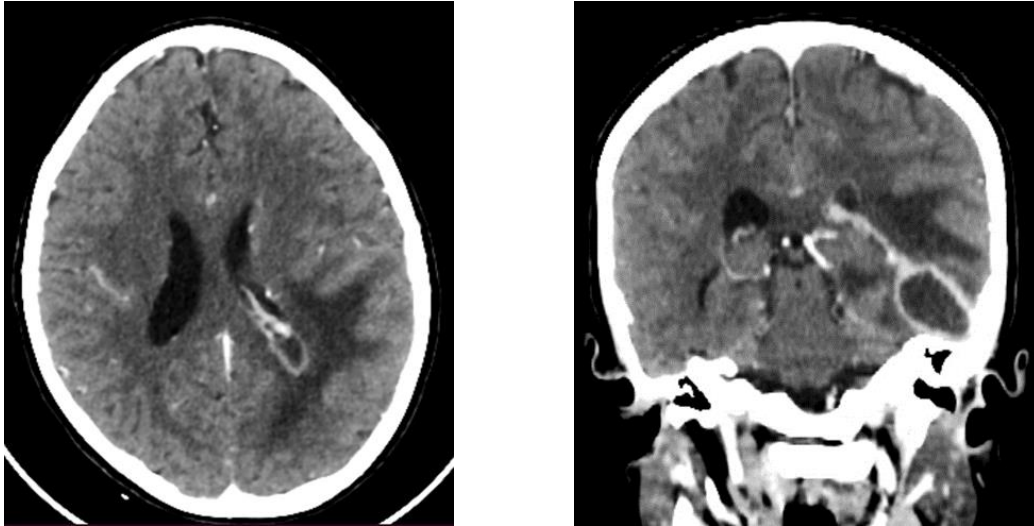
Axial and corona CT scan showing the abscess communicating with the lateral ventricle
